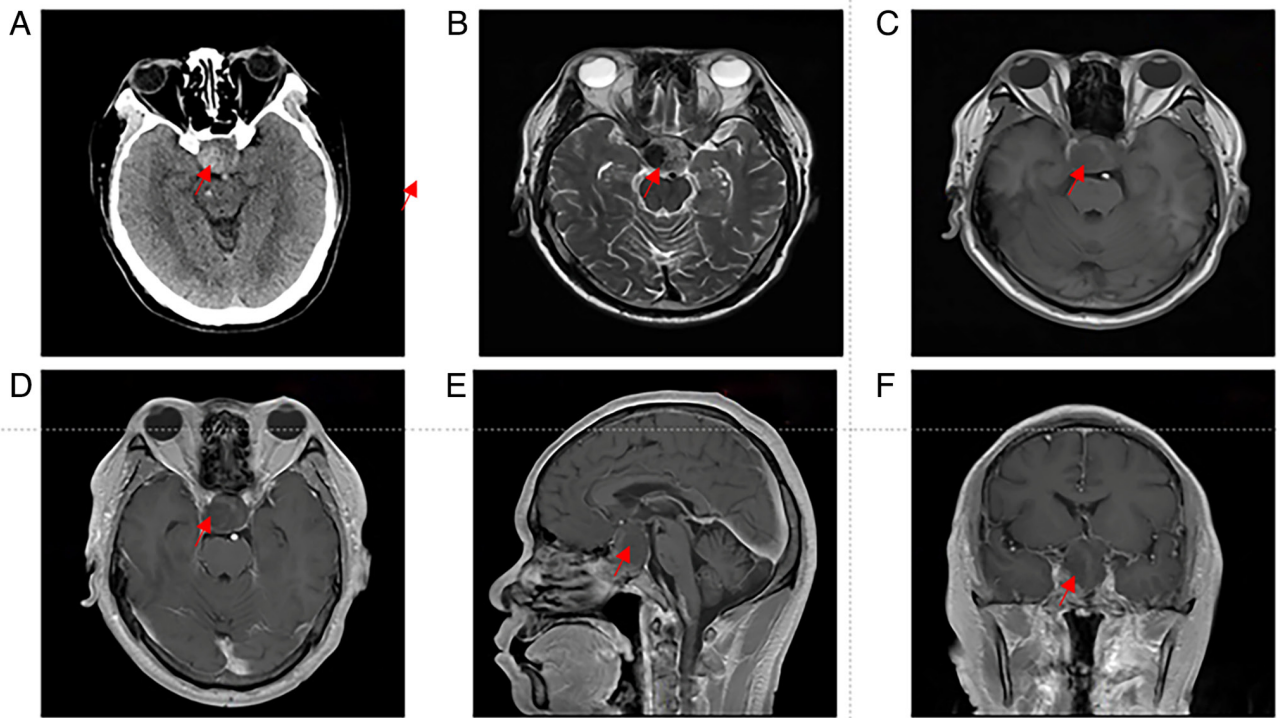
Preoperative images. (A) Preoperative computed tomography. (B-F) Preoperative magnetic resonance imaging. (B) T2-weighted image. (C) T1-weighted image. Gadolinium-enhanced (D) transverse, (E) sagittal and (F) coronal images. The red arrows indicate the lesion.
